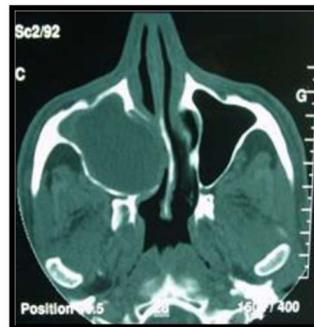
Axial computed tomographic image of the paranasal sinuses showing a completely opacified right maxillary sinus with a medial bulge of the wall of sinus and the septum.
